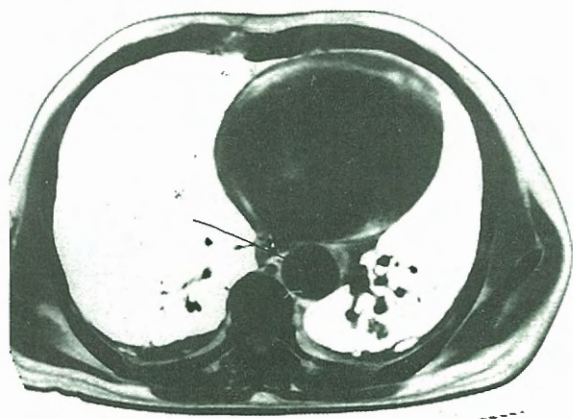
Preoperative computed tomography showing the intimal flap (arrowhead) in descending aorta.
